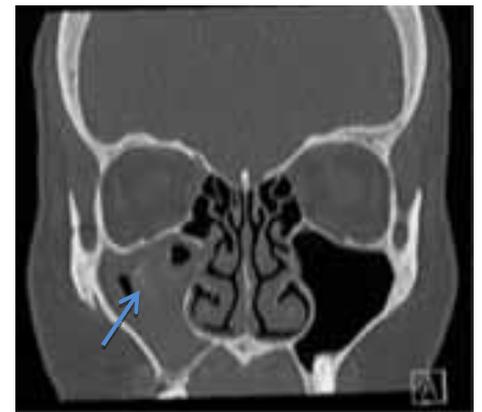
CT scan showing CRS of the right maxillary sinus. Blue arrow points to an area of increased density which frequently indicates a fungus ball.
